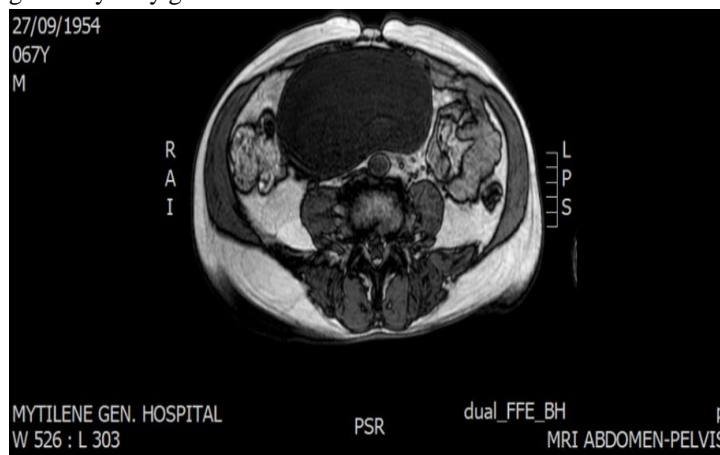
Abdominal MRI scan showing a huge cystic mass with clear margin, without contrast enhancement.
